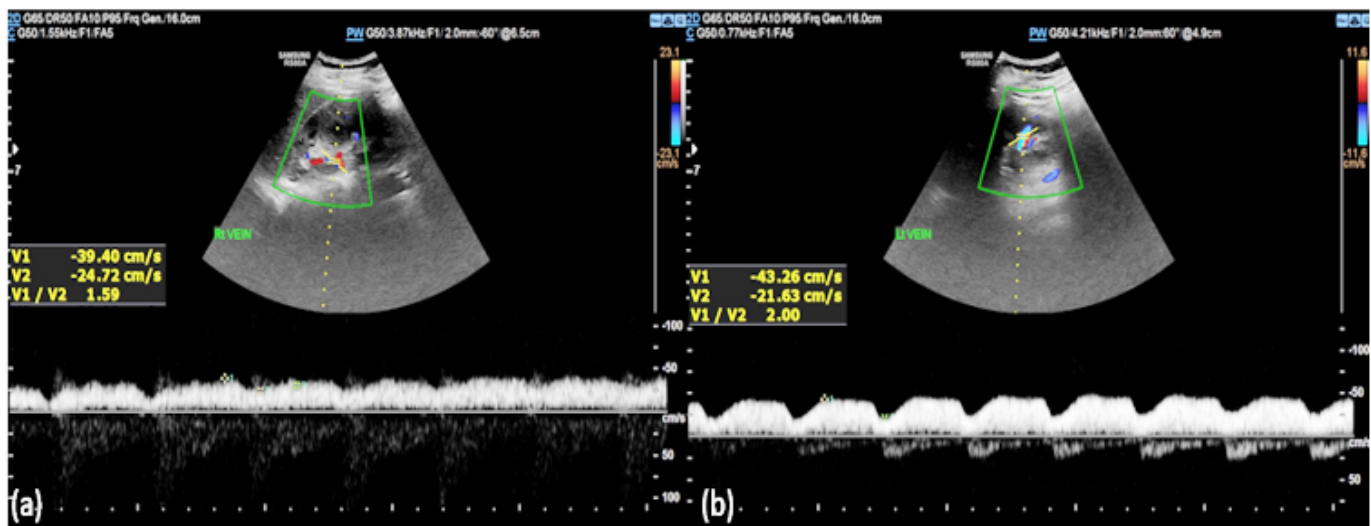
(a) & (b) — Showing Bilateral Maternal Renal Interlobar Vein Doppler Flow Indices
